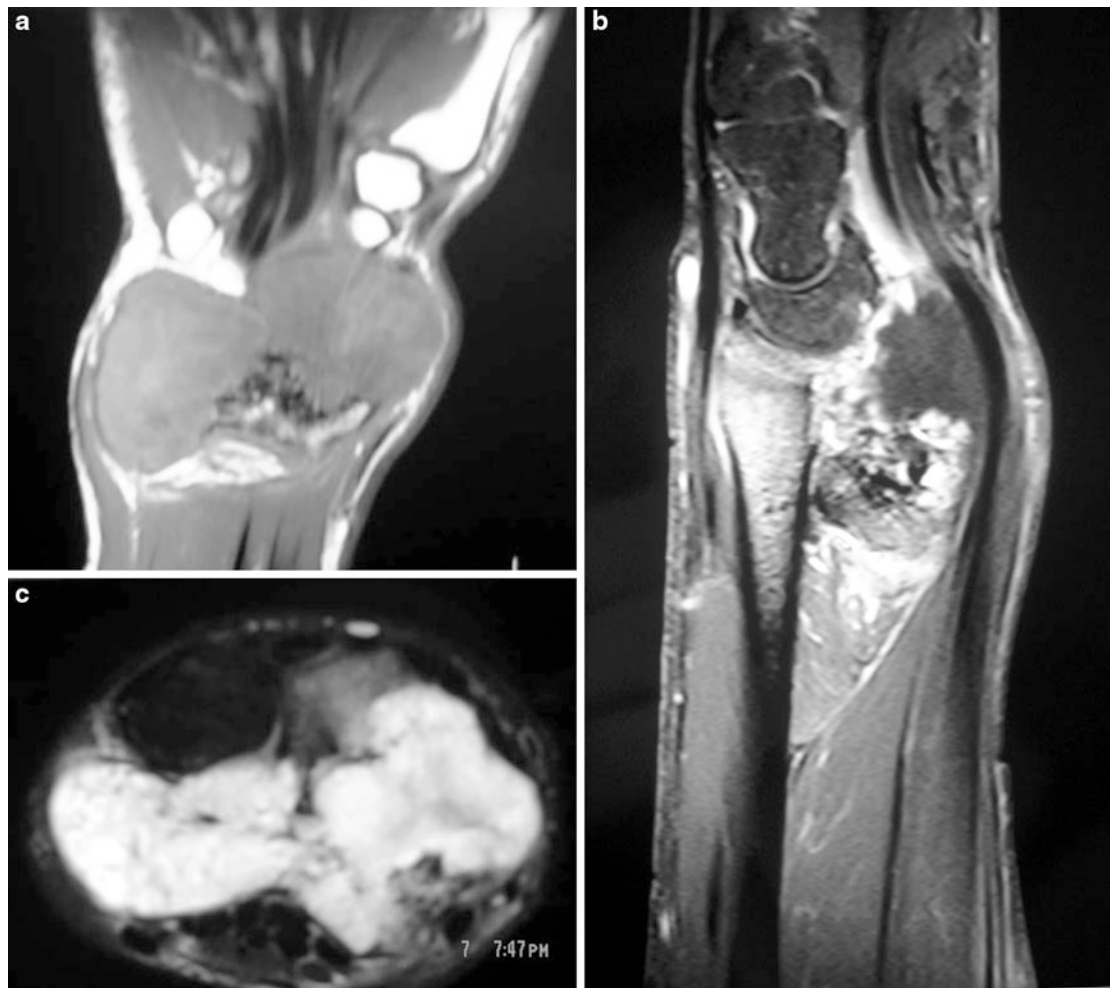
Magnetic resonance imaging of the mass reveals its expansion toward ulna and volar neurovascular structures (a, b, c)
